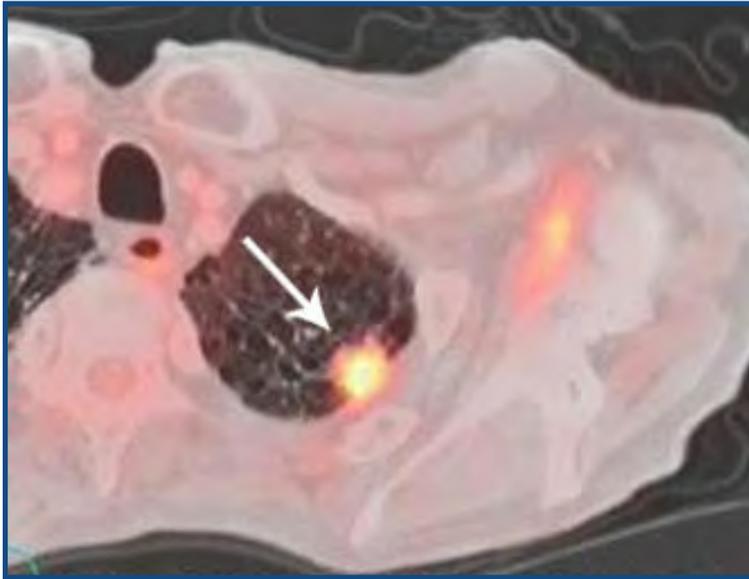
PET and CT fusion image showing hot area (arrow) is nodule subsequently proven to be a cancer.
